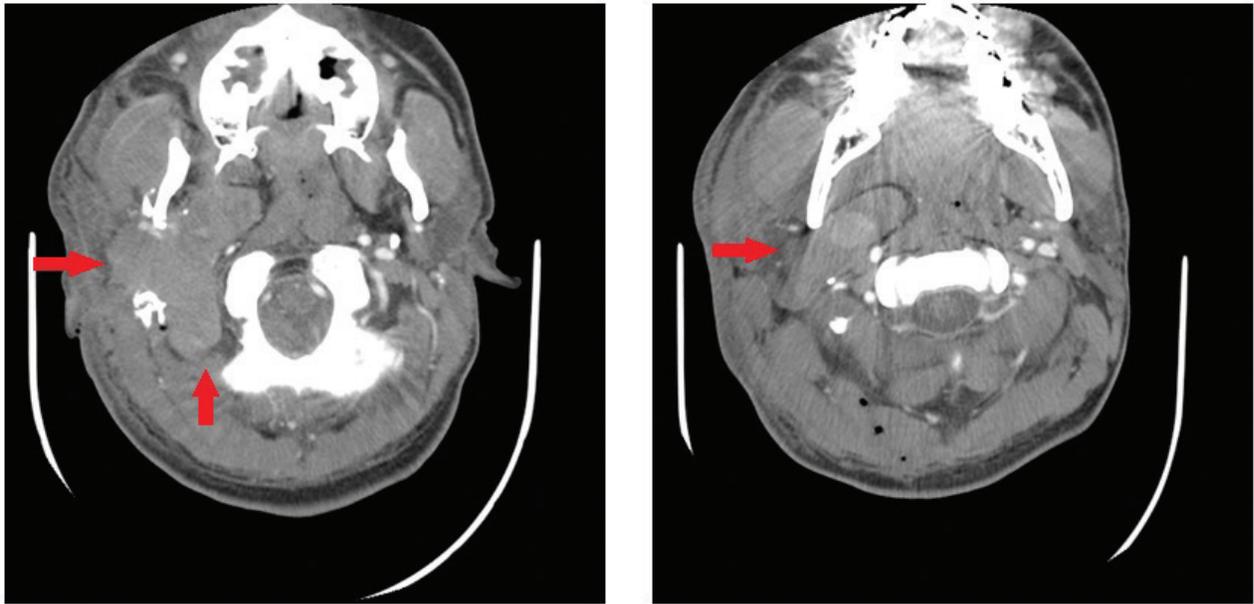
Two contrasted axial computed tomography images demonstrating extravagation at the level of the skull base in right zone III. Arrows point to the hematoma.
